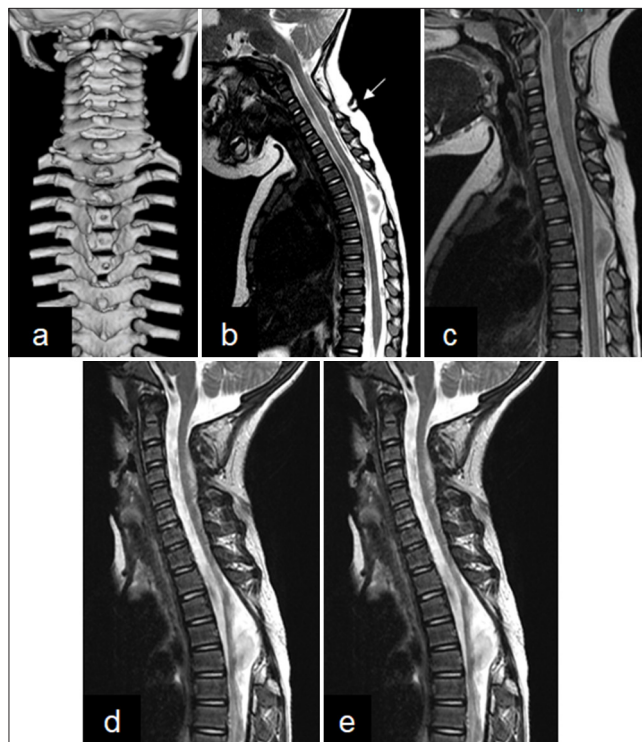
Neuro-radiological imaging during follow-up. (a) Computed tomography showed spina bifida at the cervical (C1–C5) and thoracic (T3–T5) spine. (b) Mid-sagittal T2-weighted MRI of cervical spine at age 2. The arrow indicated the skin lesion. (c–e) Mid-sagittal T2-weighted MRI of the cervical spine at age 2 (c), age 10 (d), and age 14 (e). No obvious high-signal-intensity in the cervical spinal cord. MRI: Magnetic resonance imaging.
